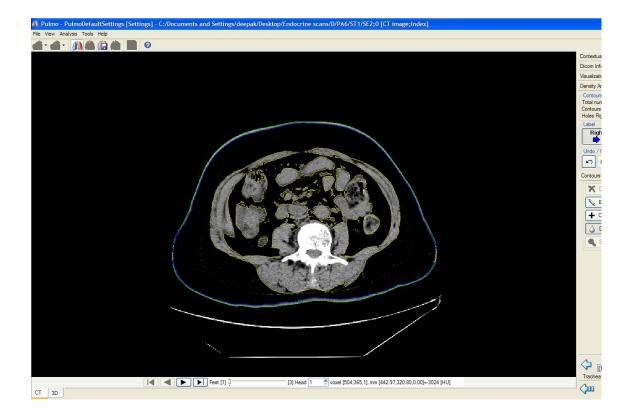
Screenshot of CT scan slice at level of L3 with region of interest drawn around the entire slice to measure total fat including visceral and subcutaneous (blue line around perimeter of slice). The software automatically selects out areas on the scan that are outside the range of threshold values of -50 to -250.
